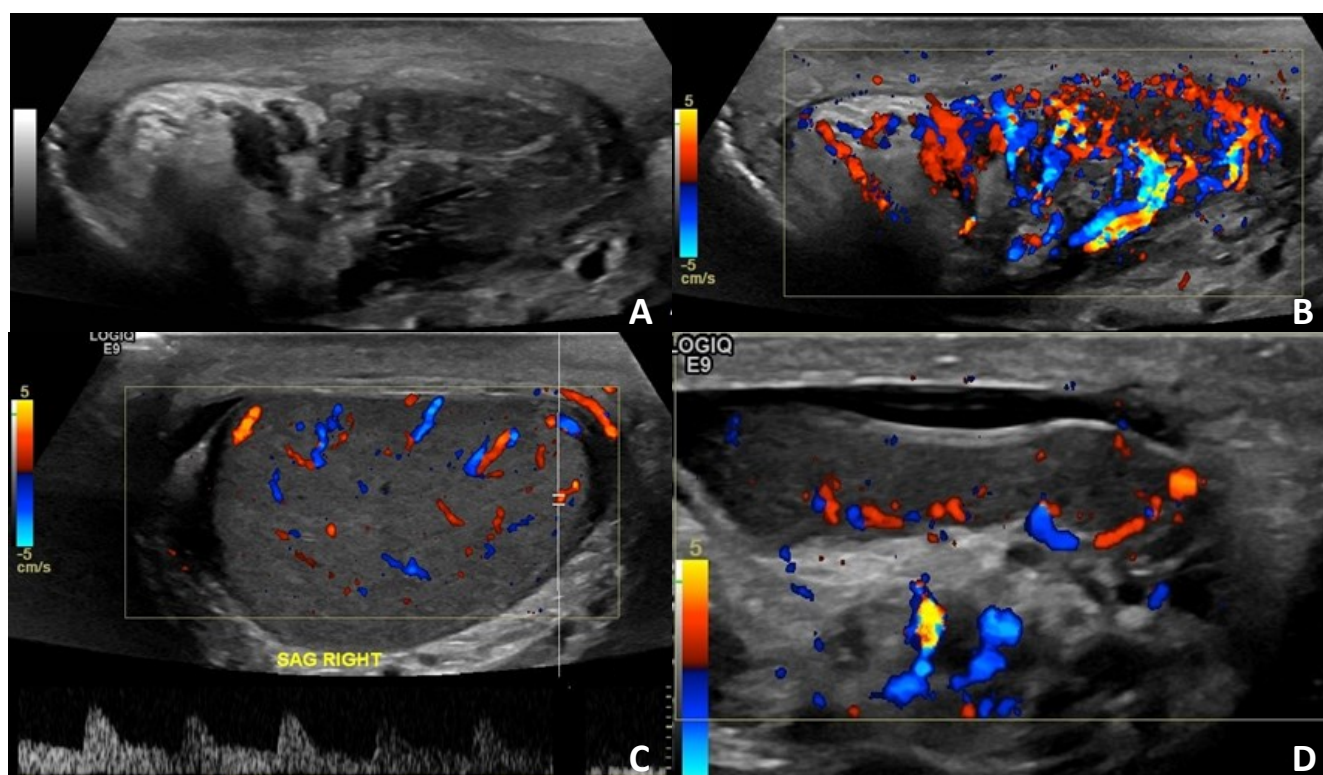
Sagittal gray-scale (A) and color Doppler (B) ultrasound images of the right scrotum demonstrate an enlarged, heterogeneous, and hypervascular epididymis. Color and spectral Doppler sonogram (C) of the right testis shows normal blood flow and perfusion. Color Doppler ultrasound image of the contralateral left epididymis (D) demonstrates normal color flow and perfusion.
